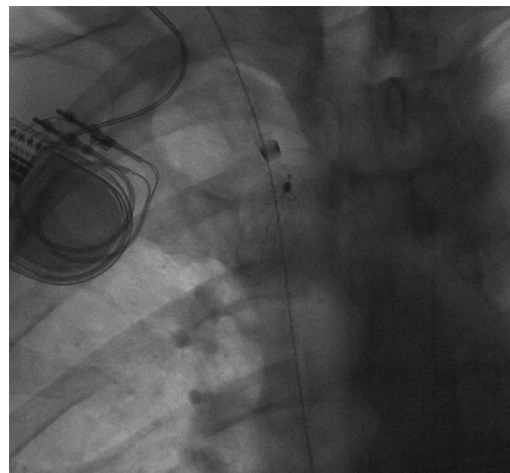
A radiograph demonstrating the filter deployed in the superior vena cava, adjacent to a guidewire and the vascular sheath
